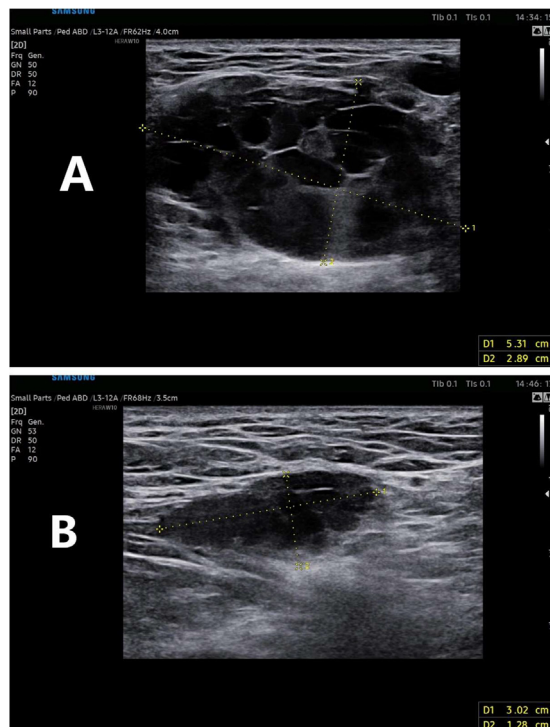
Two-dimensional ultrasound (2D) of the inguinal region shows a twisted thickened tubular echogenicity visible within and no thrombus detected within the tube. (A) Left inguinal region; (B) right inguinal region.
